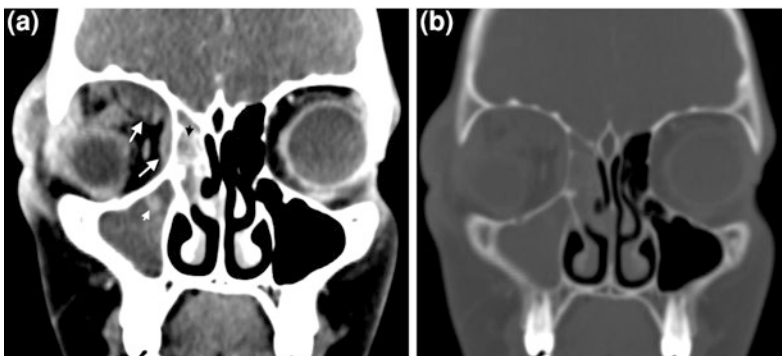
A-13-year-old boy with sub-periosteal abscess Coronal CT image demonstrates right orbital extraconal superior and medial orbital marginally enhancing fluid collections, consistent with subperiosteal abscess (arrows). Opacified right ethmoidal air cells and right maxillary antrum with soft tissue density with hyperdense content likely due to fungal infection/inspissated secretion (arrow heads)
